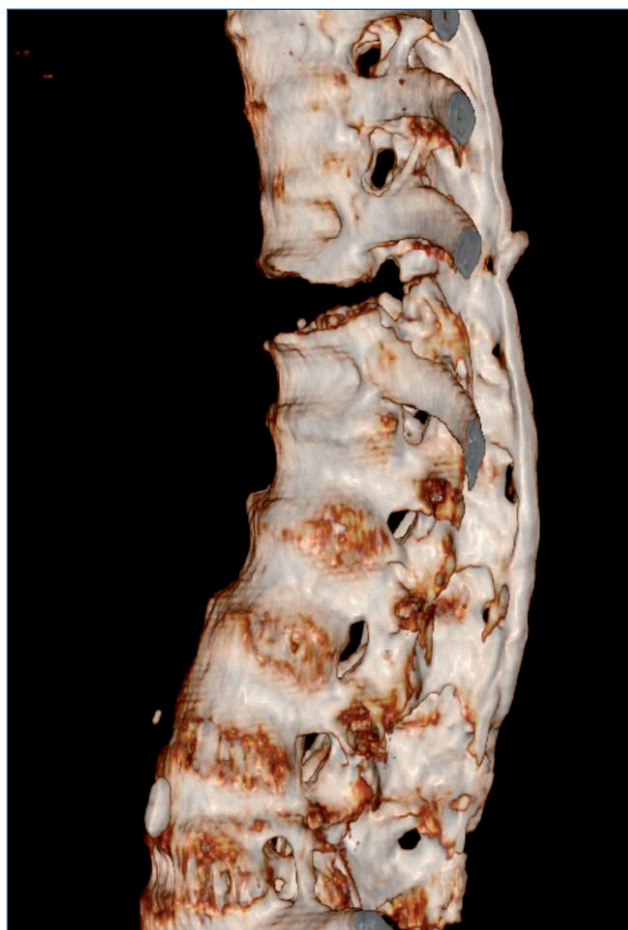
Separations of the intervertebral disc T11-12 on 3D CT.
